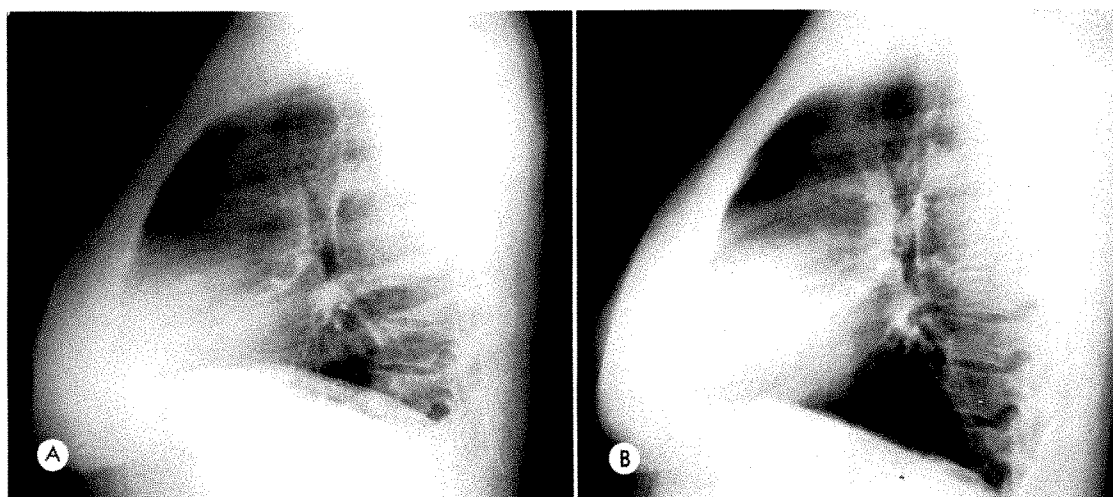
Same patient as in Figure 2. (A) Conventional lateral chest roentgenogram. (B) High kilovoltage lateral chest roentgenogram, using a grid but not the wedge filter, also shows the overpenetrated apices.
